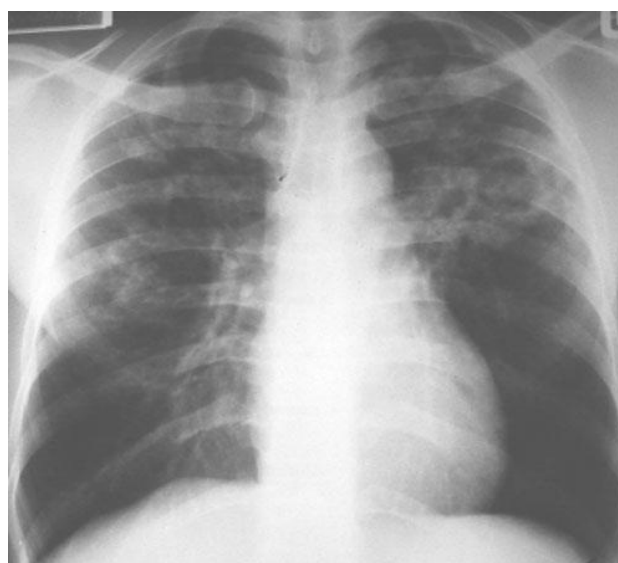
PA chest X-ray of HIV - negative PTB subject that shows multiple thick walled cavitory lesions involving the upper and mid lung zones bilaterally. Patchy opacities are noted as in both zones as well with sparing of the lower lung zone
